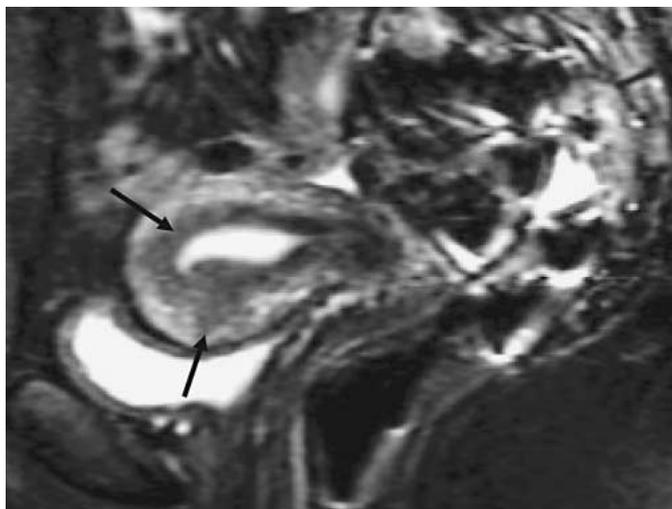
T2-weighted magnetic resonance image of the uterus. The arrows point to the diffuse thickening of the endometrial-myometrial junctional zone which is consistent with adenomyosis.
